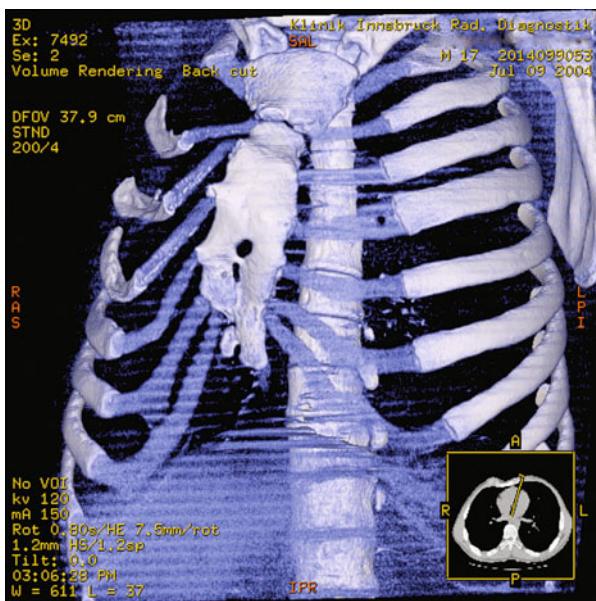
Volume rendering 3D CT scan of an 18-year old male with major pectus arcuatum deformity and minor cleft sternum deformity
